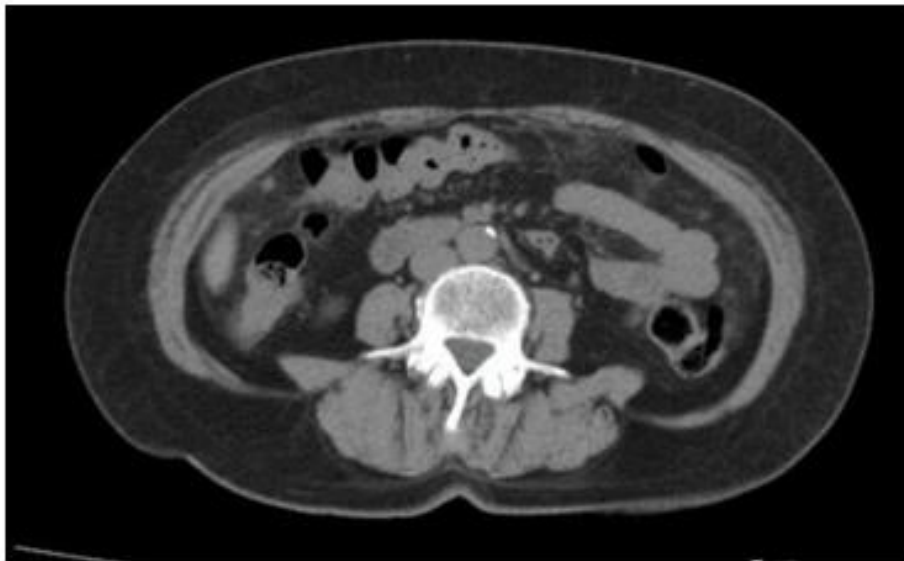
Abdominal CT scan with contrast, increased fat density in the omentum, nodules suggestive of carcinomatosis.
